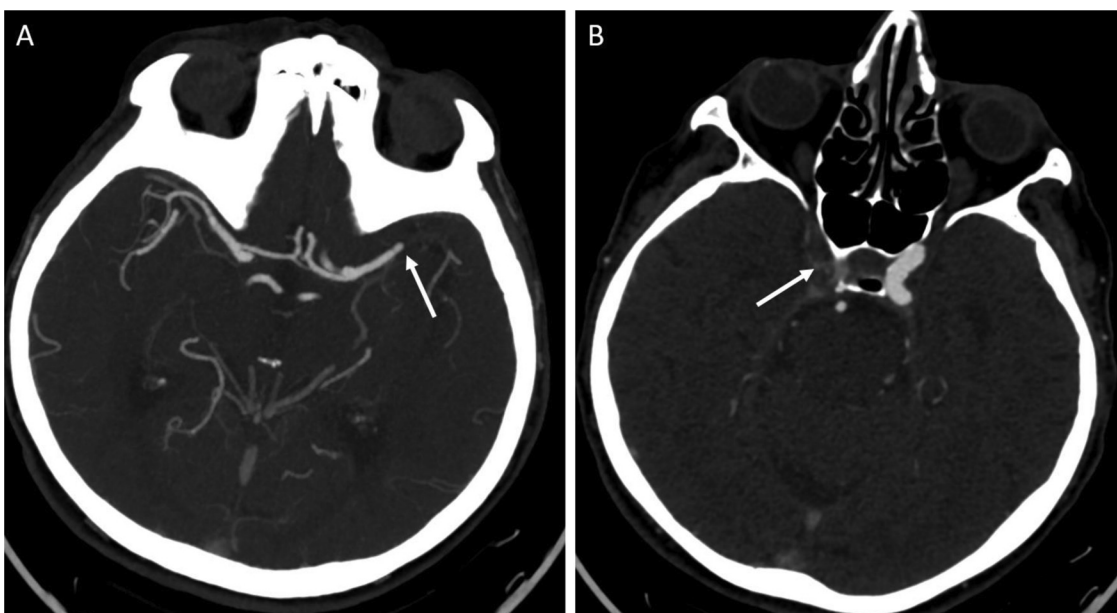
CT angiography, axial images (A, B): there is an acute occlusion of the left MCA in part M1/M2 (A) as well as the chronic occlusion of the left internal carotid artery (B) (arrows).
